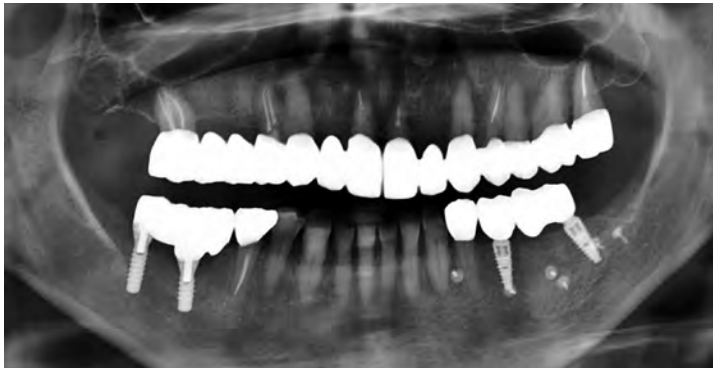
3-year follow-up panoramic x-ray.
